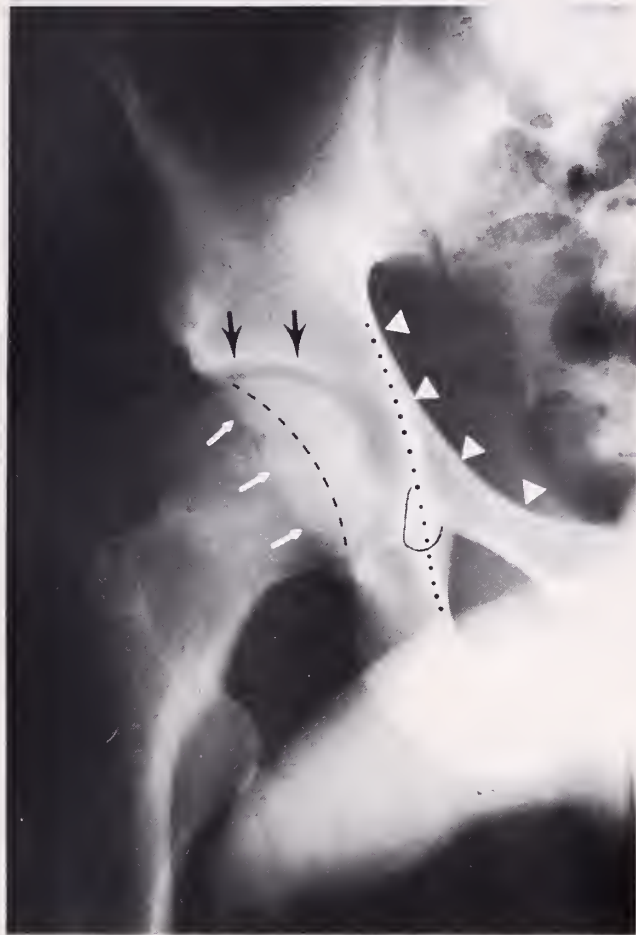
Normal radiographic anatomy of the acetabulum. Six lines are identifiable in the AP projection. (1) White arrowheads identify the iliopectic line (anterior column). (2) Dotted line identifies the ilioischial line (posterior column). (3) U-shaped line outlines the "teardrop" or roentgen U; this is formed laterally by the medial wall of acetabulum and medially by the anterior portion of the quadrilateral plate. (4) Black arrows mark the acetabular roof. (5) Dashed line identifies the anterior lip of the acetabulum. (6) White arrows mark the posterior lip of the acetabulum.
